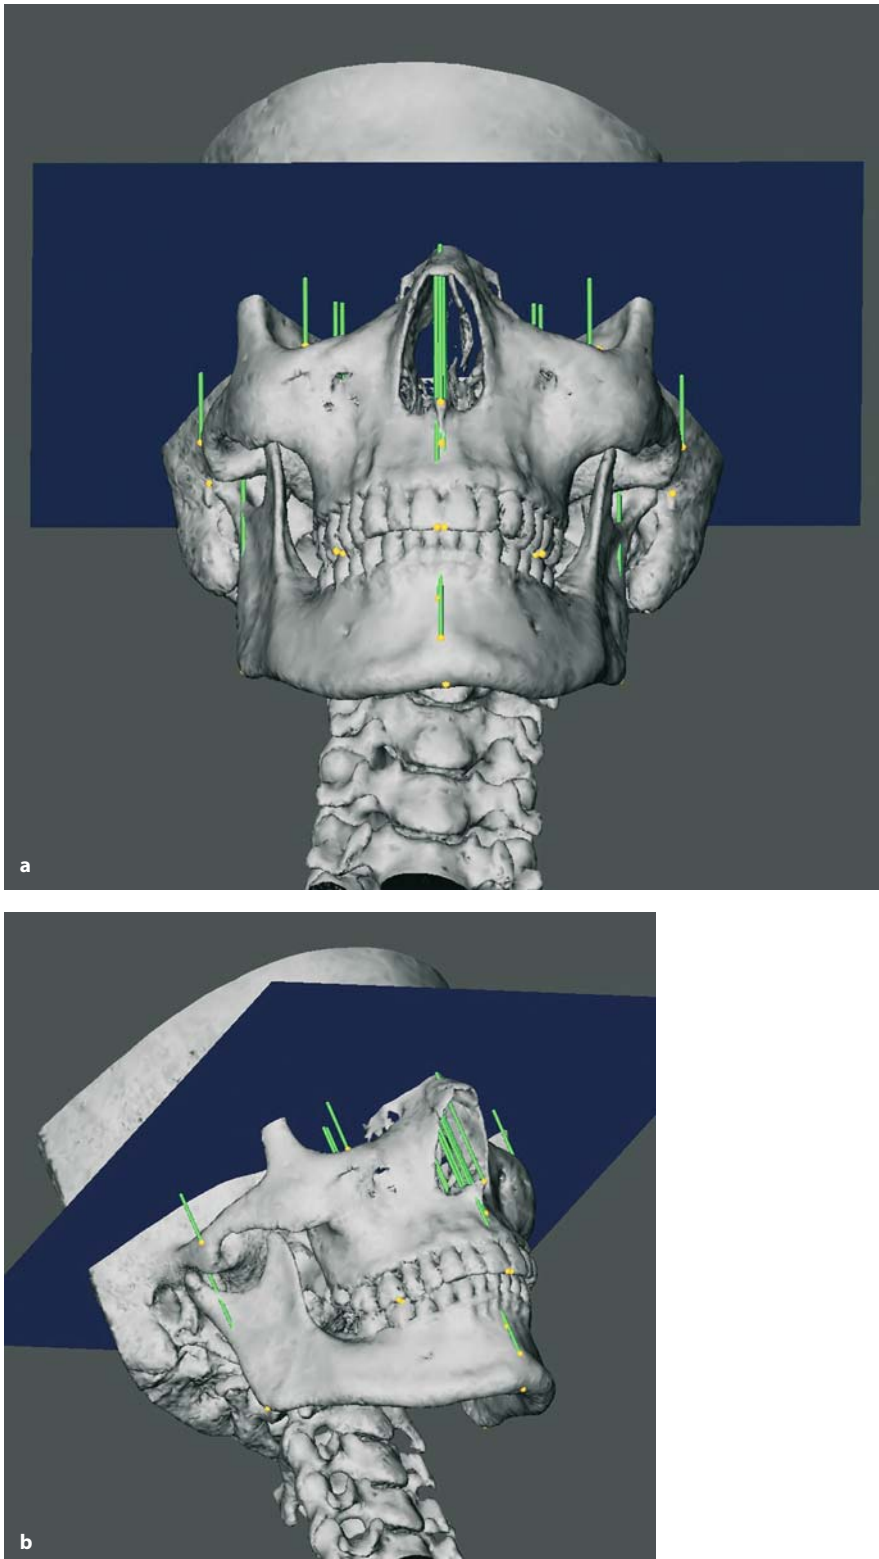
a, b. Set-up of vertical orthogonal hard tissue measurements to the horizontal (x) plane (3-D CT, patient K.C.)
